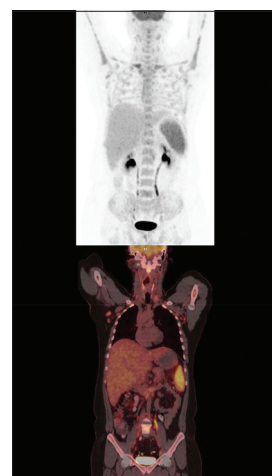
Positron emission tomography-computed tomography image showing lymph node and reticuloendothelial uptake
